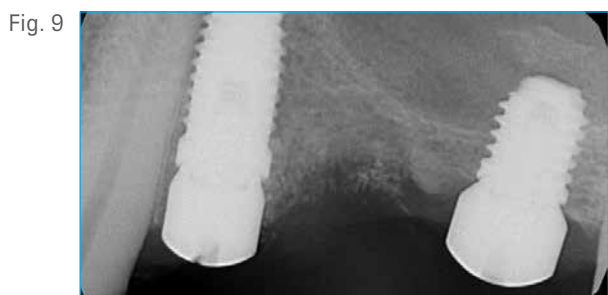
Postoperative radiograph. Note the T3® Short Implant of 6 mm length partially invading the sinus.
